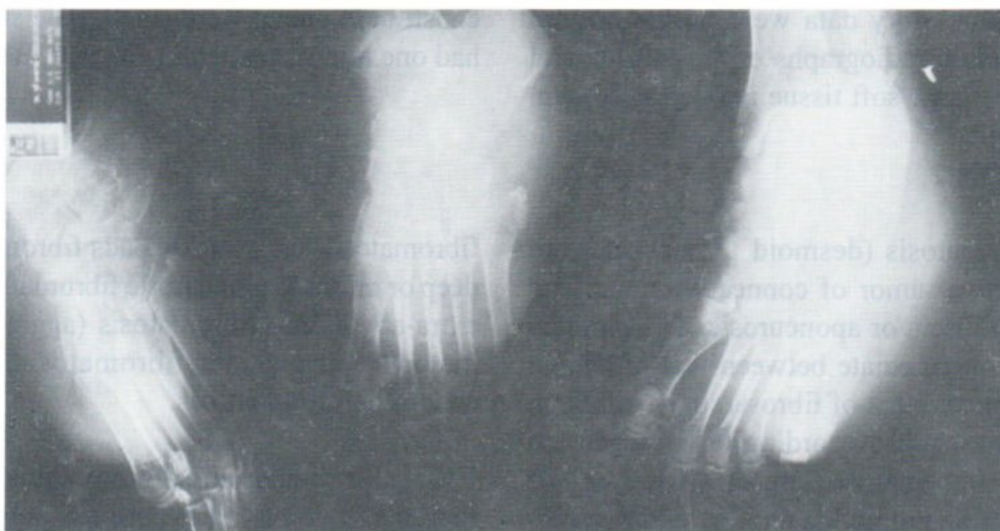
Plain radiograph left foot (AP, lateral, oblique) showing soft tissue mass of dorsal foot with well defined cystic changes of tarsal bone or pressure erosion.
